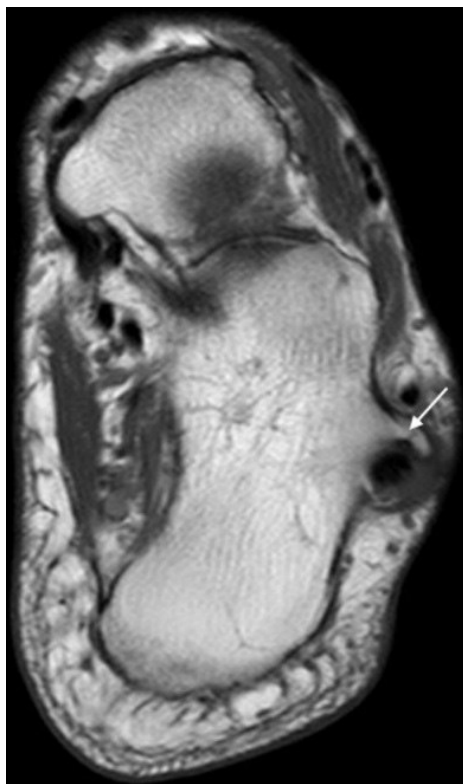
Coronal MRI of the left foot. A hypertrophied peroneal tubercle (indicated by arrow)
